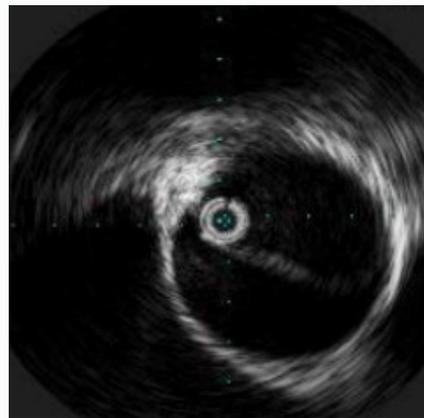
Intravascular ultrasound with presence of a 1 cm aortic dissection.
